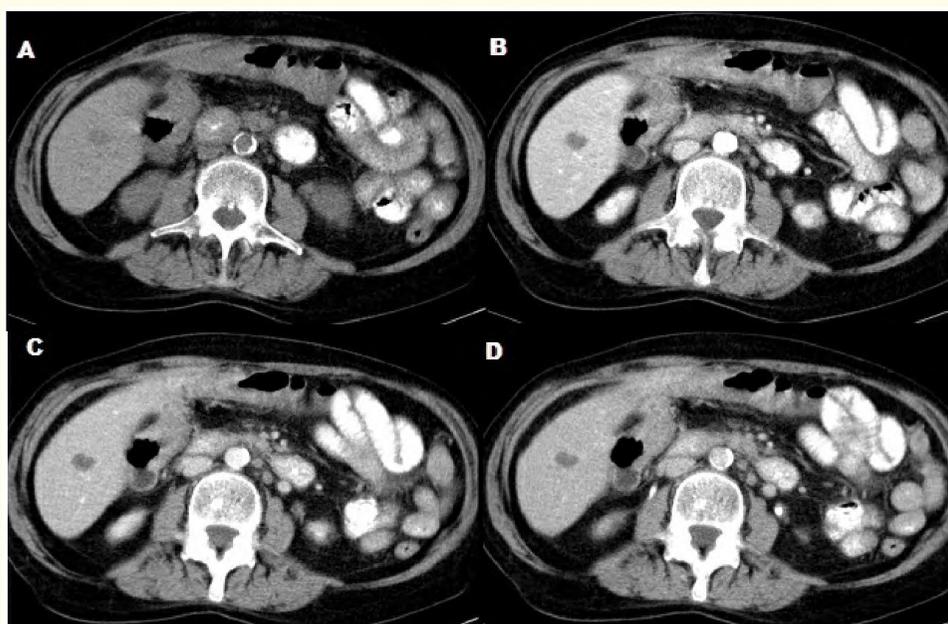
Abdominal and pelvic CT (February 2018) – A. native phase, B. arterial phase, C. venous phase, D. parenchymal phase: single hepatic cystic metastasis.
